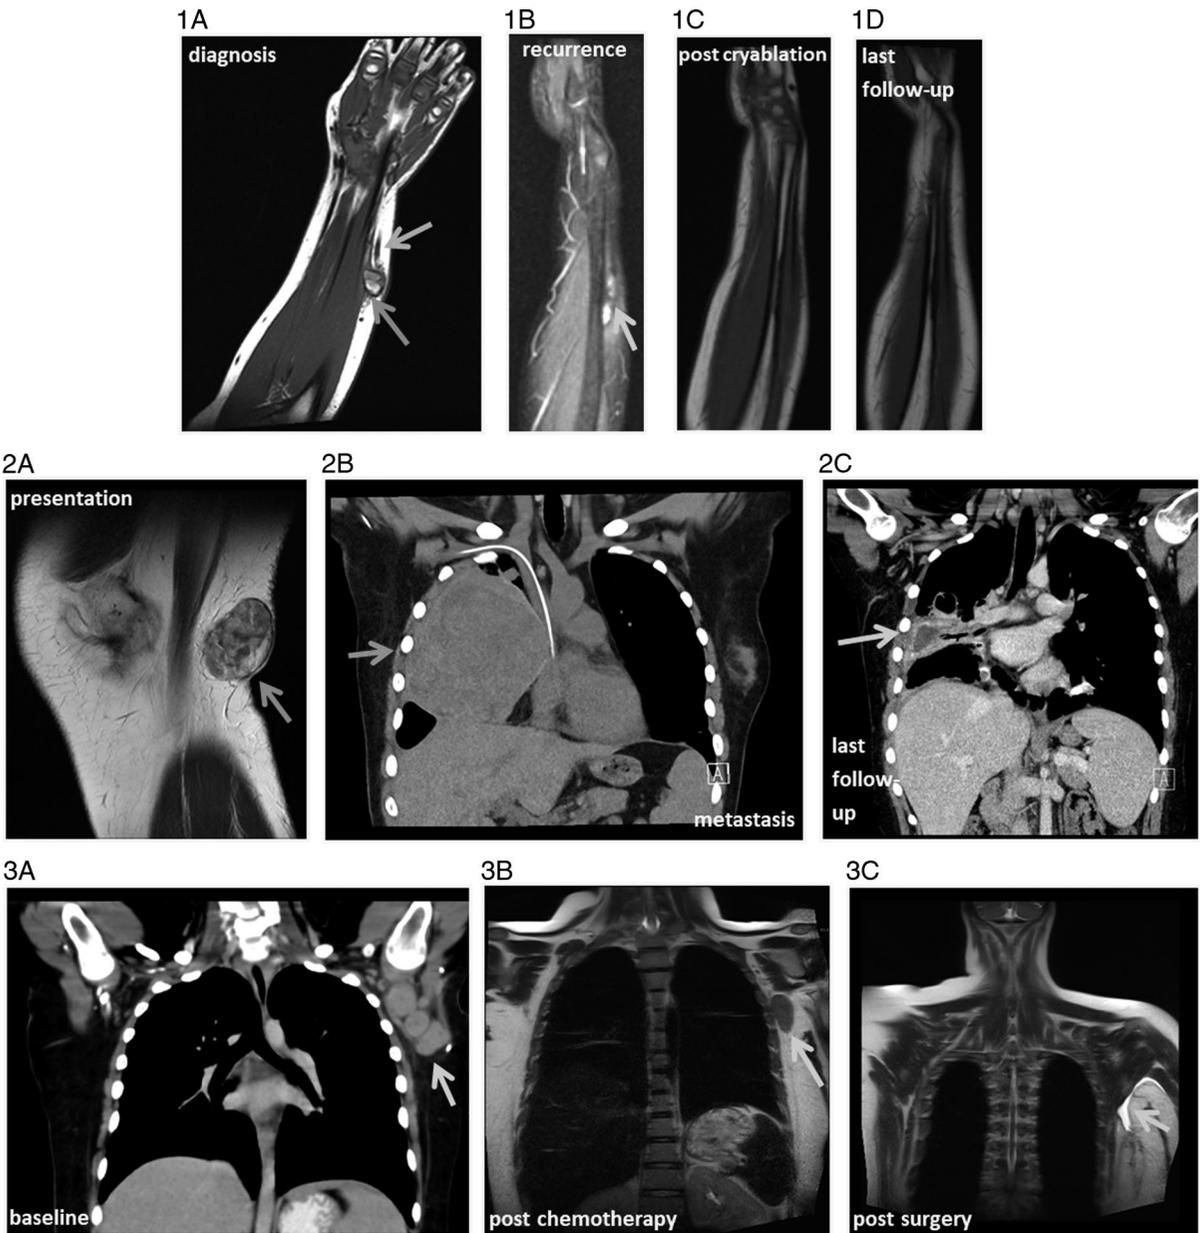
CASE 1: 1. A, Magnetic resonance imaging (MRI) image at presentation. An ovoid well-circumscribed subcutaneous heterogeneous lesion (red arrow) with vascularized solid and fluid components alongside both central and a peripheral rim of blood products; a dominant draining vein (lavender arrow) drained the neoplasm. The mass was intimately related to the lateral surface of the underlying musculature with a small projection into the underlying intermuscular plane. There was perilesional subcutaneous edema. 1. B, Intramuscular recurrence developed at the proximal right forearm surgical bed and in the ipsilateral distal forearm associated with palpable right axillary lymphadenopathy, appreciable on a positron emission tomography/computed tomography (CT) scan as 18F-fluorodeoxyglucose-avid foci. 1. C, MRI image postchemotherapy and cryoablation. 1. D, Surveillance MRI demonstrating complete remission. CASE 2: 2. A, Red arrow—left popliteal heterogenous mass showing a peripheral vascularized rim. 2. B, Blue arrow—CT demonstrating metastatic disease in middle pulmonary lobe. 2. C, Green arrow—shrinkage of all metastases post paclitaxel, gradual necrosis, and air changes replaced part of the solid component in the middle lobe mass, which remained stable for 6 months alongside a couple of subpleural nodules in the right upper lobe. Resolution of infradiaphragmatic lymphadenopathy resolved and shrinkage of hepatosplenic deposits. CASE 3: 3. A, Baseline CT at our centre; demonstrated 3 metabolically active discrete left axillary masses. 3. B, Orange arrow—shrinkage of left axillary masses after chemotherapy. 3. C, Postoperative MRI demonstrating seromas (green arrow), but no residual disease was appreciable at the surgical bed on MRI.
